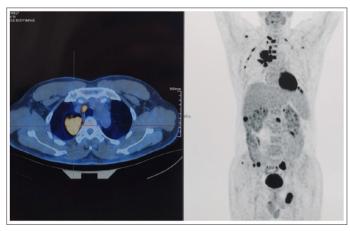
PET-CT showing the primary tumor in the lung (left) and the multiple metastases (right) all over the body including lung and nearby lymph nodes, peritoneal metastases, liver, bone and muscles.
